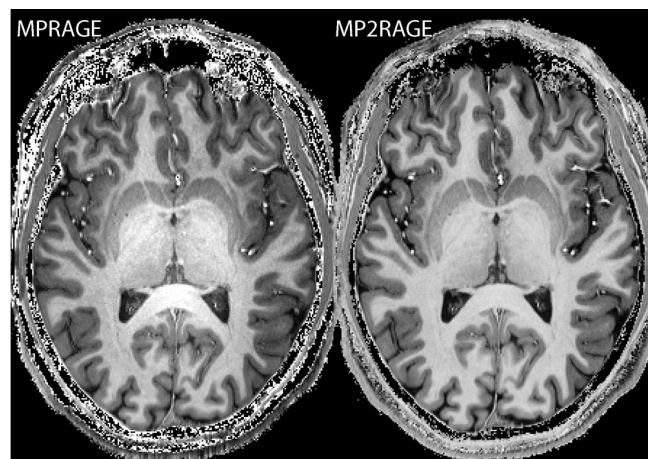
7 T MRI T1-weighted MPRAGE divided by GE (left) and MP2RAGE (right) with 0.7 mm isotropic resolution.
